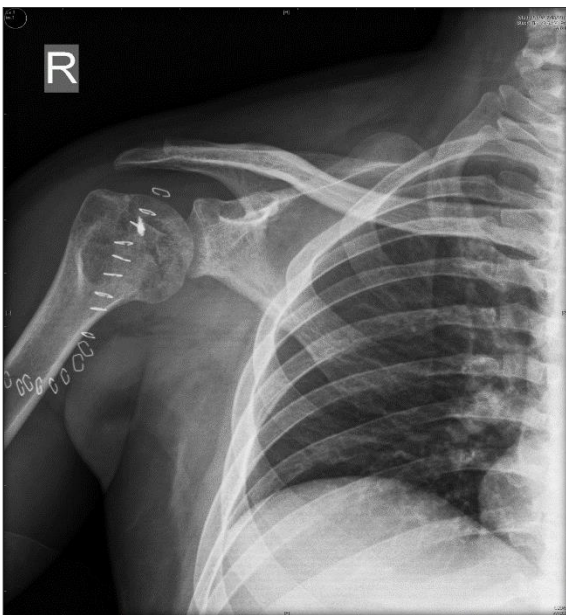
Immediate postoperative anteroposterior radiographs (Patient 1) showing normal humeral head shape and excellent joint congruency
